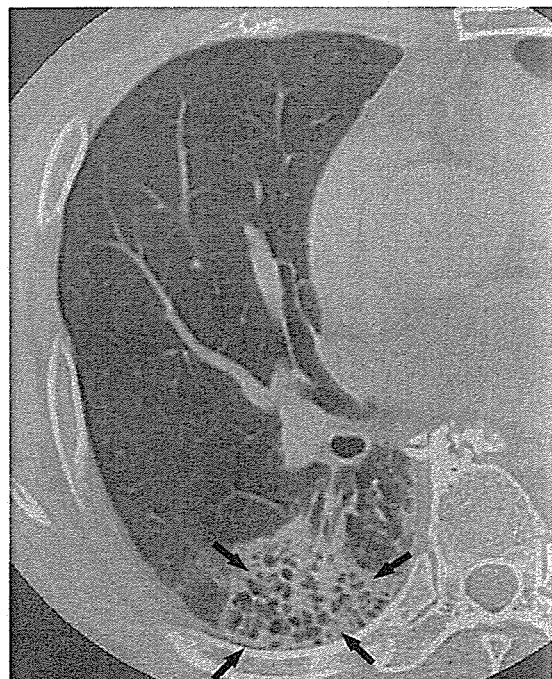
Mucin-producing adenocarcinoma of the lung in a 76-year-old man. Thin-section computed tomography image shows areas of air-space consolidation with bubble-like lucencies (arrows).
